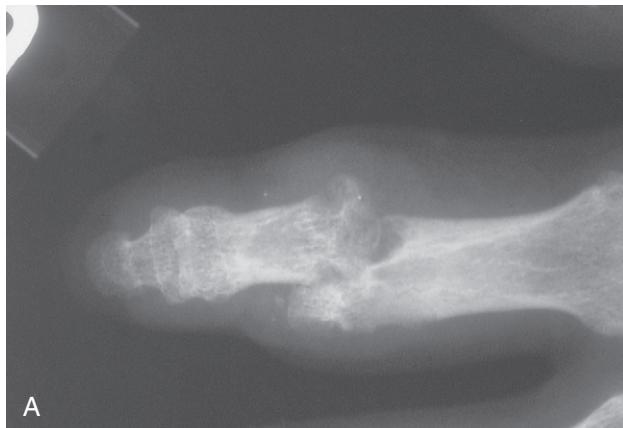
A and B, Radiographs demonstrating severe destructive changes in tophaceous gout.
